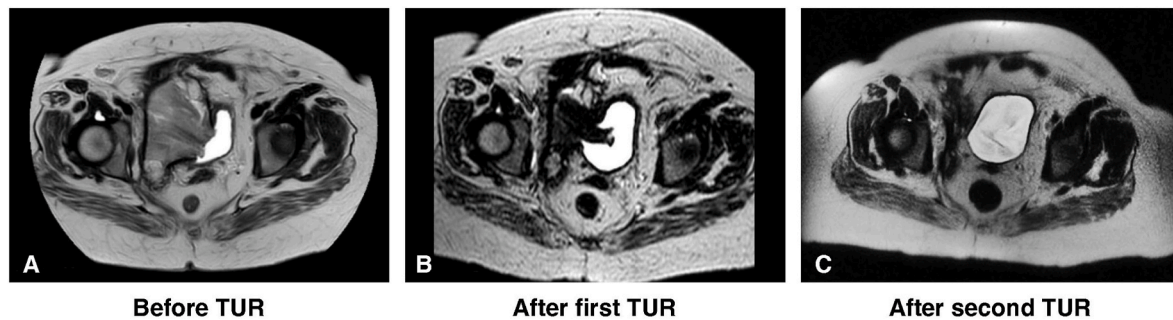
Serial cross-sectional MR imaging of bladder hematoma.
